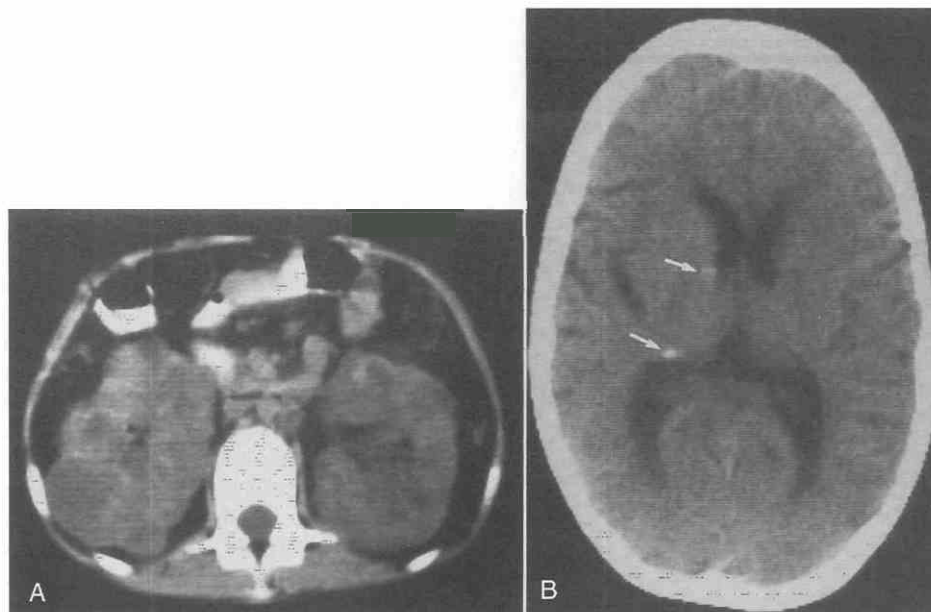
Tuberous sclerosis with renal cystic disease in a 14-year-old female. *A*, Unenhanced CT scan displays kidneys containing multiple cysts. No fat-containing angiomyolipomas were detected. *B*, A cranial CT scan reveals paraventricular calcifications (arrows), indicating diagnosis of tuberous sclerosis and permitting differentiation from autosomal dominant polycystic kidney disease.
